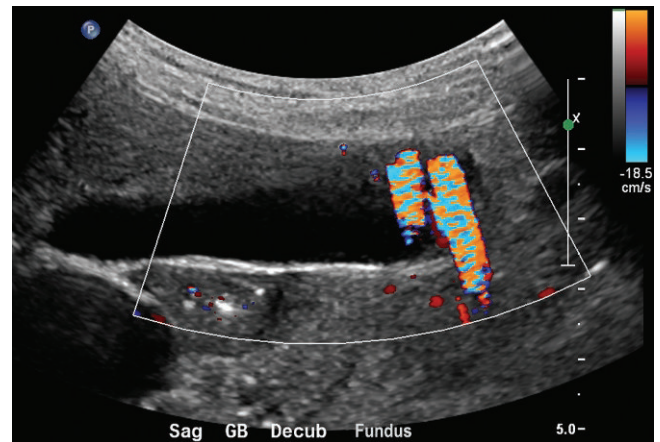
In the gallbladder fundus, there is a heterogeneous soft tissue density. On color Doppler nonmobile material in the area creates the twinkle artifact, which extends some distance behind a bright reflector. This helps confirm the diagnosis of adenomyomatosis. Irregular calcification produces the artifact.
